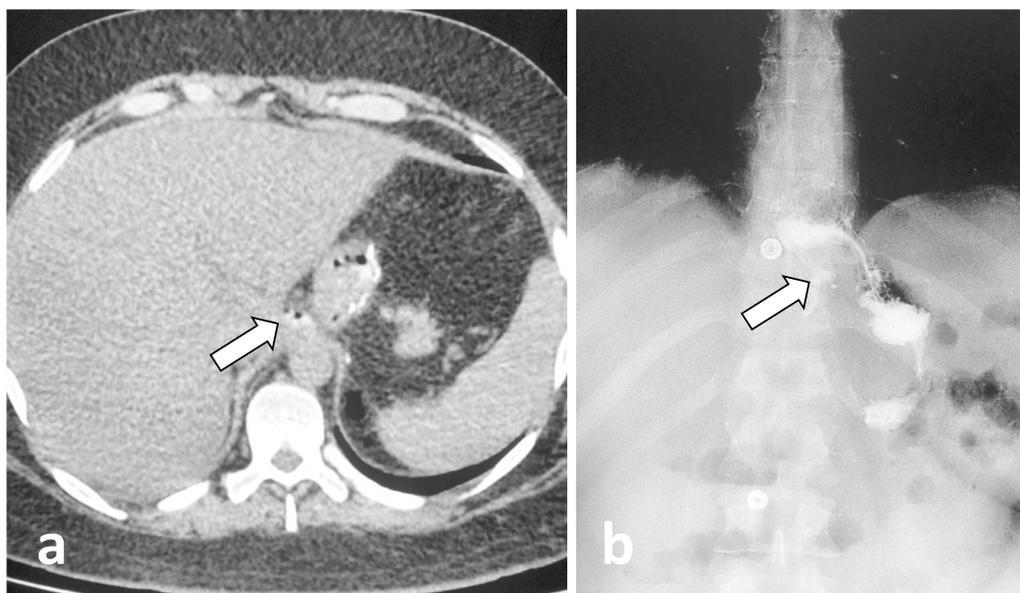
Post LSG a Axial-enhanced MDCT and b Water-soluble UGI fluoroscopic examination showing evidence of contrast leakage related to the superior aspect of the staples line with evidence of extra-luminal oral contrast and air foci more evident in the CT image (arrows)
